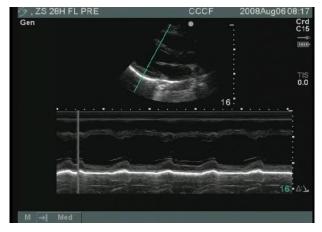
M-Mode Echocardiography to Measure Ejection Fraction and Fractional Shortening
